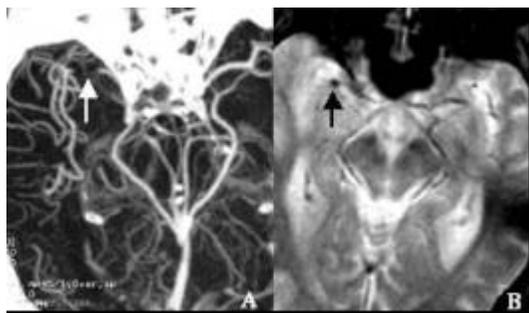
Right MCA occlusion. CTA at 1.68 hours after symptom onset (A) shows a MCA stem occlusion (arrow). SI at 9.9 hours (B) shows a small susceptibility sign in area of MCA stem (arrow) that may suggest a large part of the embolus is diamagnetic.
